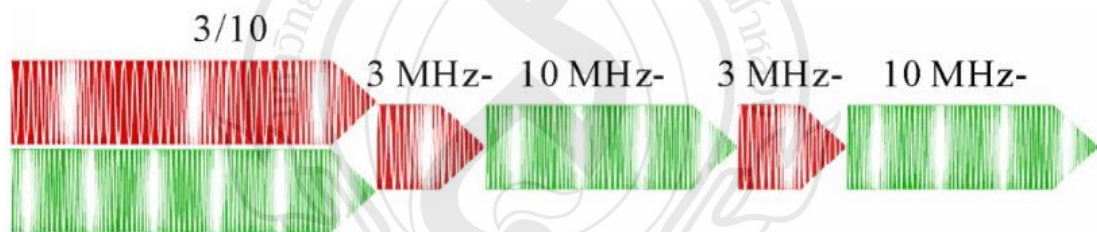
Wave formation in dual frequency ultrasound
